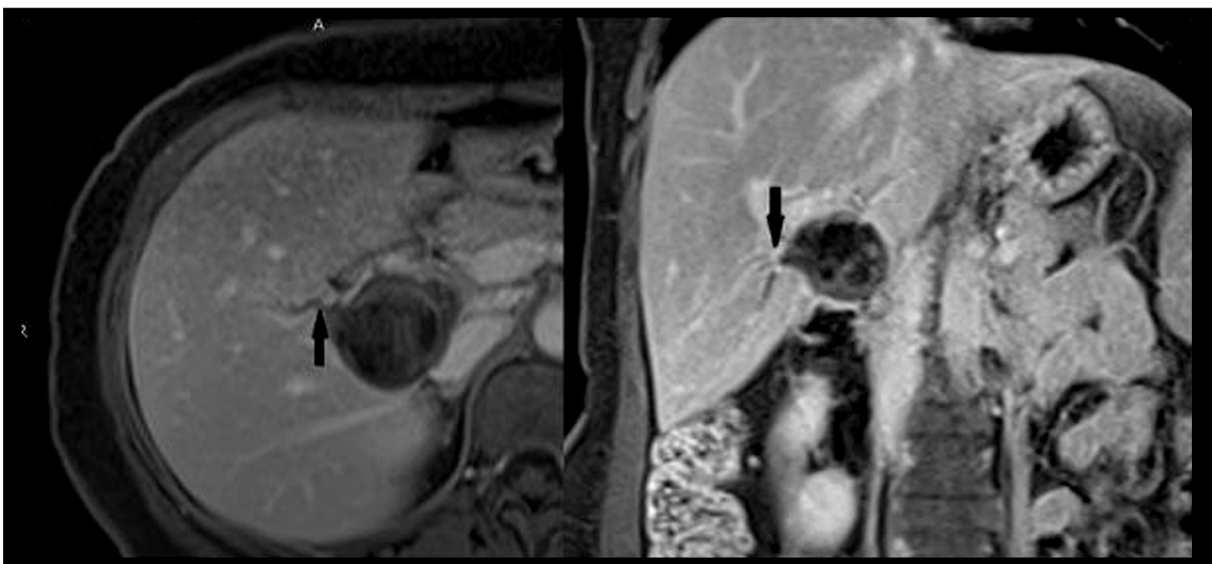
Axial and coronal contrast-enhanced fat-suppressed T1 MRI sequences show no contrast enhancement in the lesion, a fine fistula (black arrow) between the lesion and the intrahepatic bile ducts at the level of segment V, and mild dilatation in the intrahepatic bile ducts.
